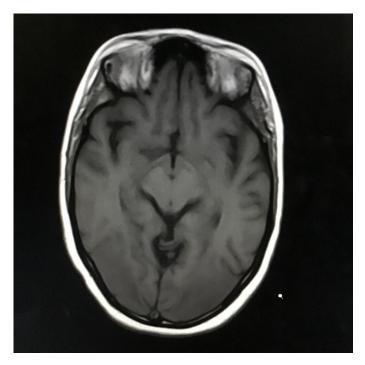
MRI Brain Axial T1 weighted image showing hypointensity in bilateral; occipital lobes.
